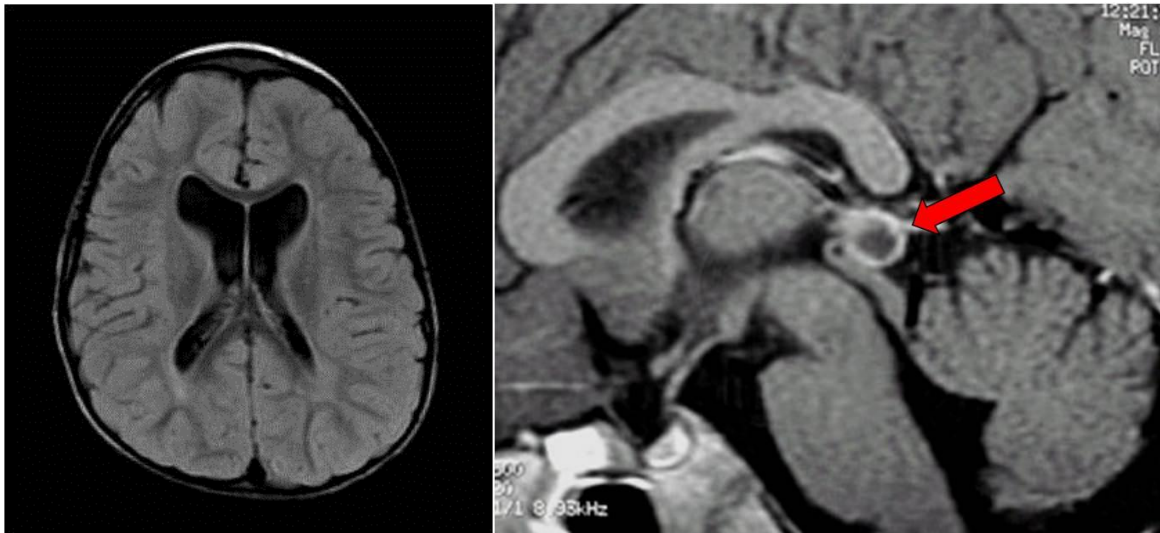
MRI scans. Cortical dysplasia.
